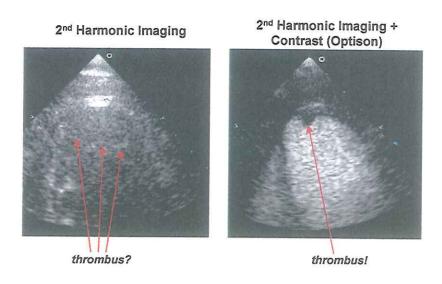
Zoomed apical 4 chamber views in a patient who had suffered a large anterior infarct and was due to have CABG. His routine (harmonic) transthoracic echo, seen on the left, had suggested a large apical thrombus which the surgeons wanted to remove. As shown, he was a poor echo subject and a thrombus could not be definitely confirmed. Since the presence or absence of a thrombus would affect the surgical approach, a contrast study with 2^{nd} harmonic imaging was performed and is shown on the right. This confirmed the presence of a thrombus, although it was much smaller and not in exactly the same location as the routine echo had suggested. The structure seen on the non-contrast image was in fact an anomalous chord near the apex.
